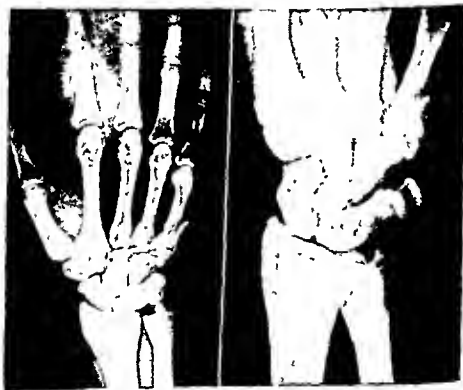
Anteroposterior and oblique roentgenograms of the left wrist showing the carpal anomaly
